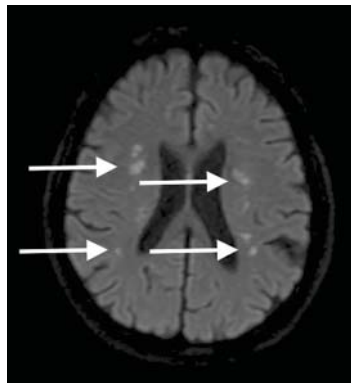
On diffusion-weighted magnetic resonance imaging several months after presentation, the multiple lesions in both hemispheres (arrows) were almost unchanged.
